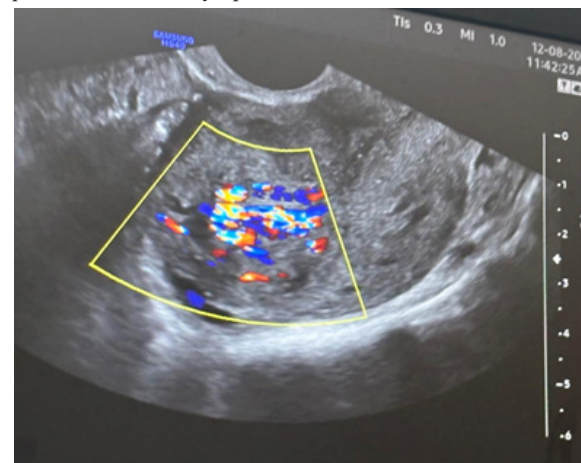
Doppler flow showing increased vascularity within the uterine AVM.
